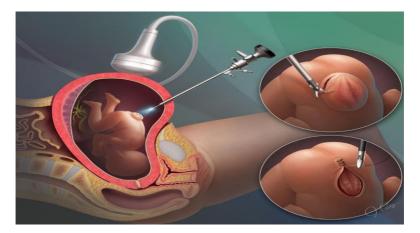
Ultrasound guided Prenatal repair of (MMC)
